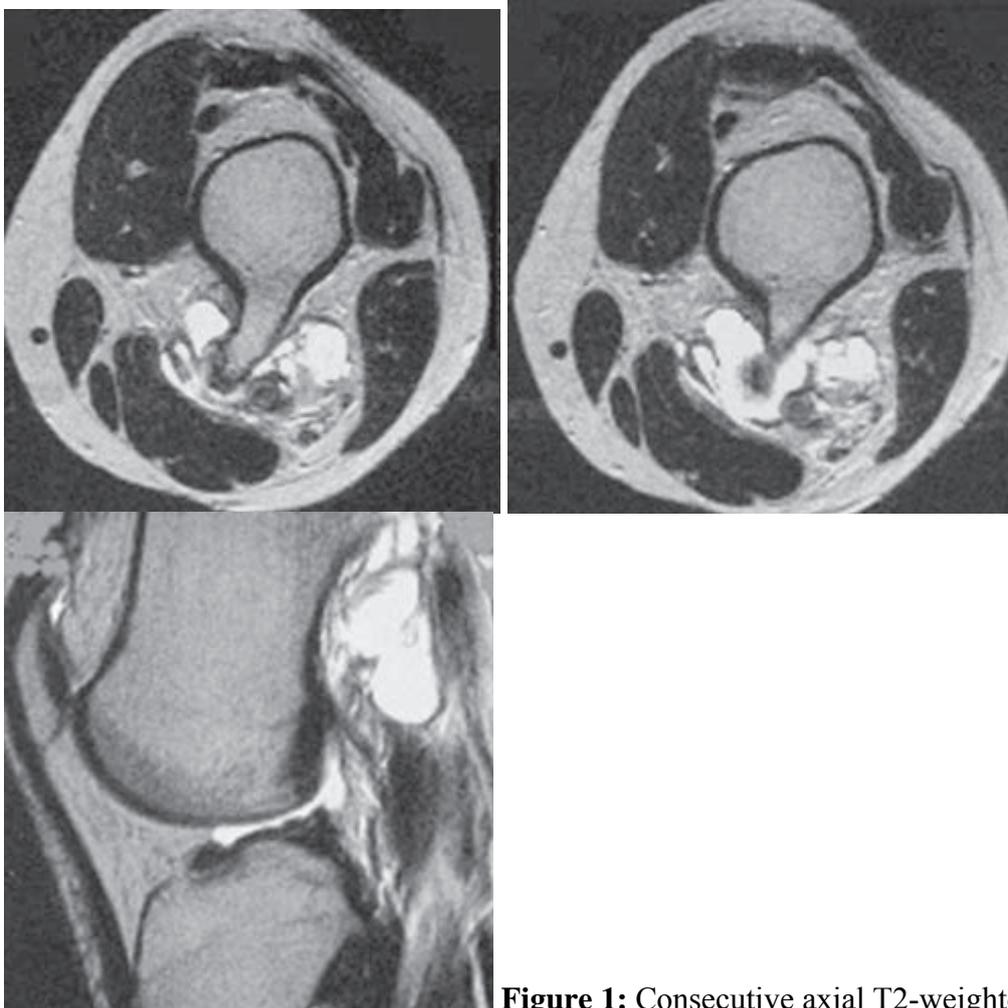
Consecutive axial T2-weighted MRIs of the left knee (A-D).
